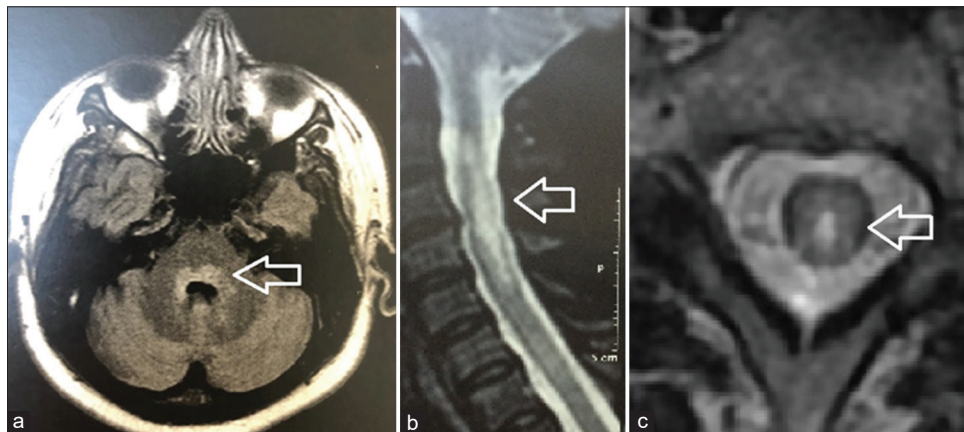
Case report image. (a)- FLAIR Axial Brain magnetic resonance imaging: Hyperintense lesion around the 4th ventricle (white arrow); (b)-T2 Sagittal cervical spinal cord; and (c)-T2 Axial cervical spinal cord: C2, C3, C4, and C5 central hyperintense lesion-longitudinal extensive transverse myelitis (white arrow)
